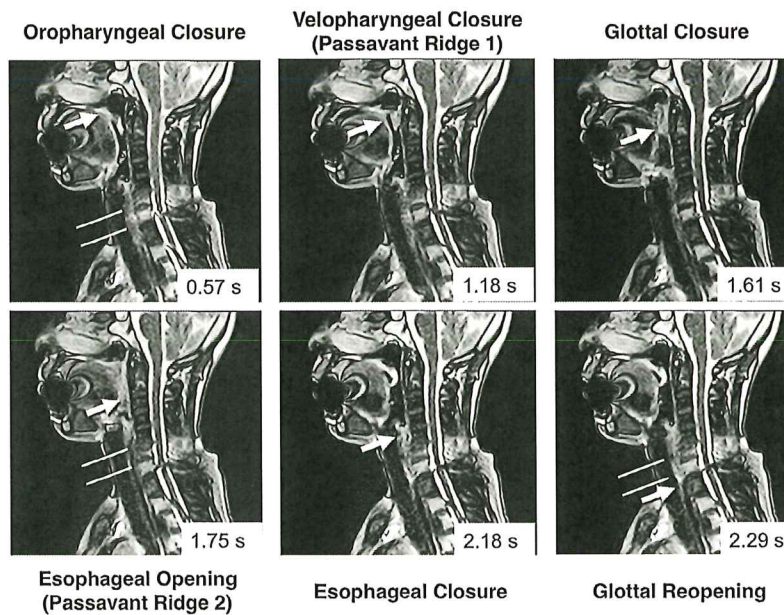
A low-quality swallowing series in the midsagittal plane obtained by using high-speed continuous magnetic resonance imaging (HSCMRI) after surgery in an 82-year-old man with cancer of the left tongue. A bright homogeneous clump in the oral regions is very unclear, and bright homogeneous areas in the whole cavity are not visualized.
